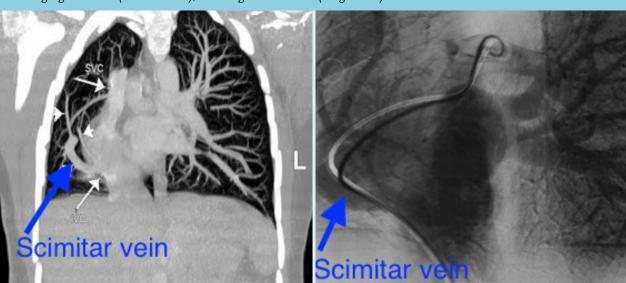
CT scan of the chest (A) and pulmonary angiography (B) showing anomalous venous return and converging branches (short arrows), draining into the IVC (long arrow)
